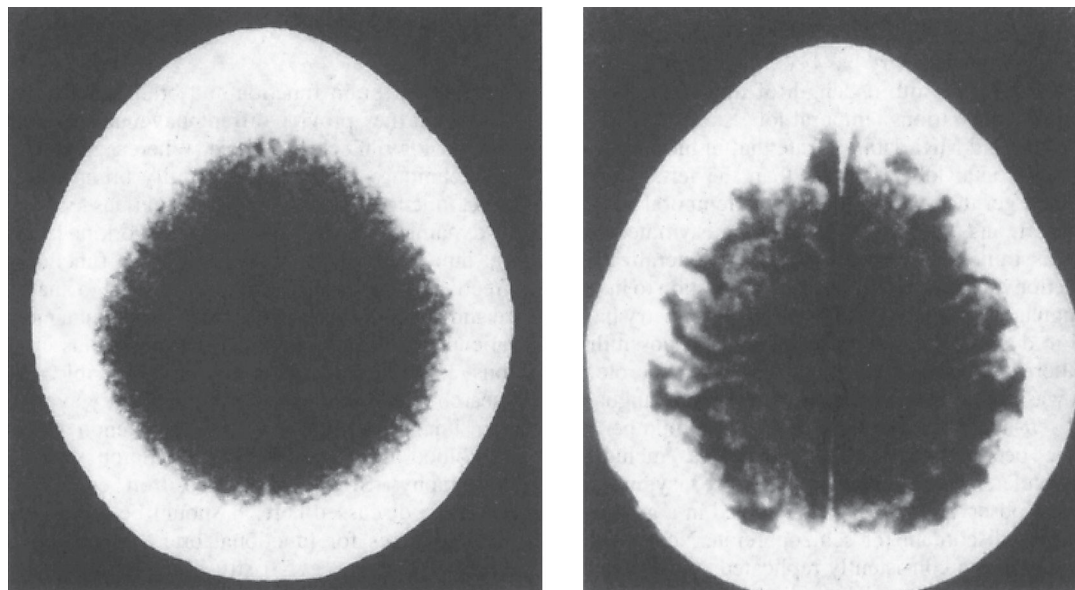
Example of computed tomography of the brain of a patient with schizophrenia (right) compared with a normal control (left).
